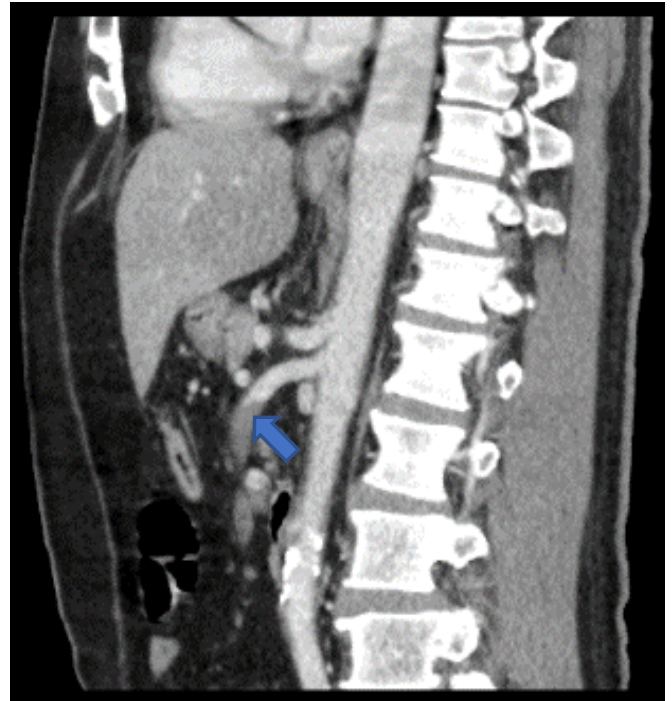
CT (sagittal view) – Total occlusion of the SMA 3cm after its emergence (blue arrow)
